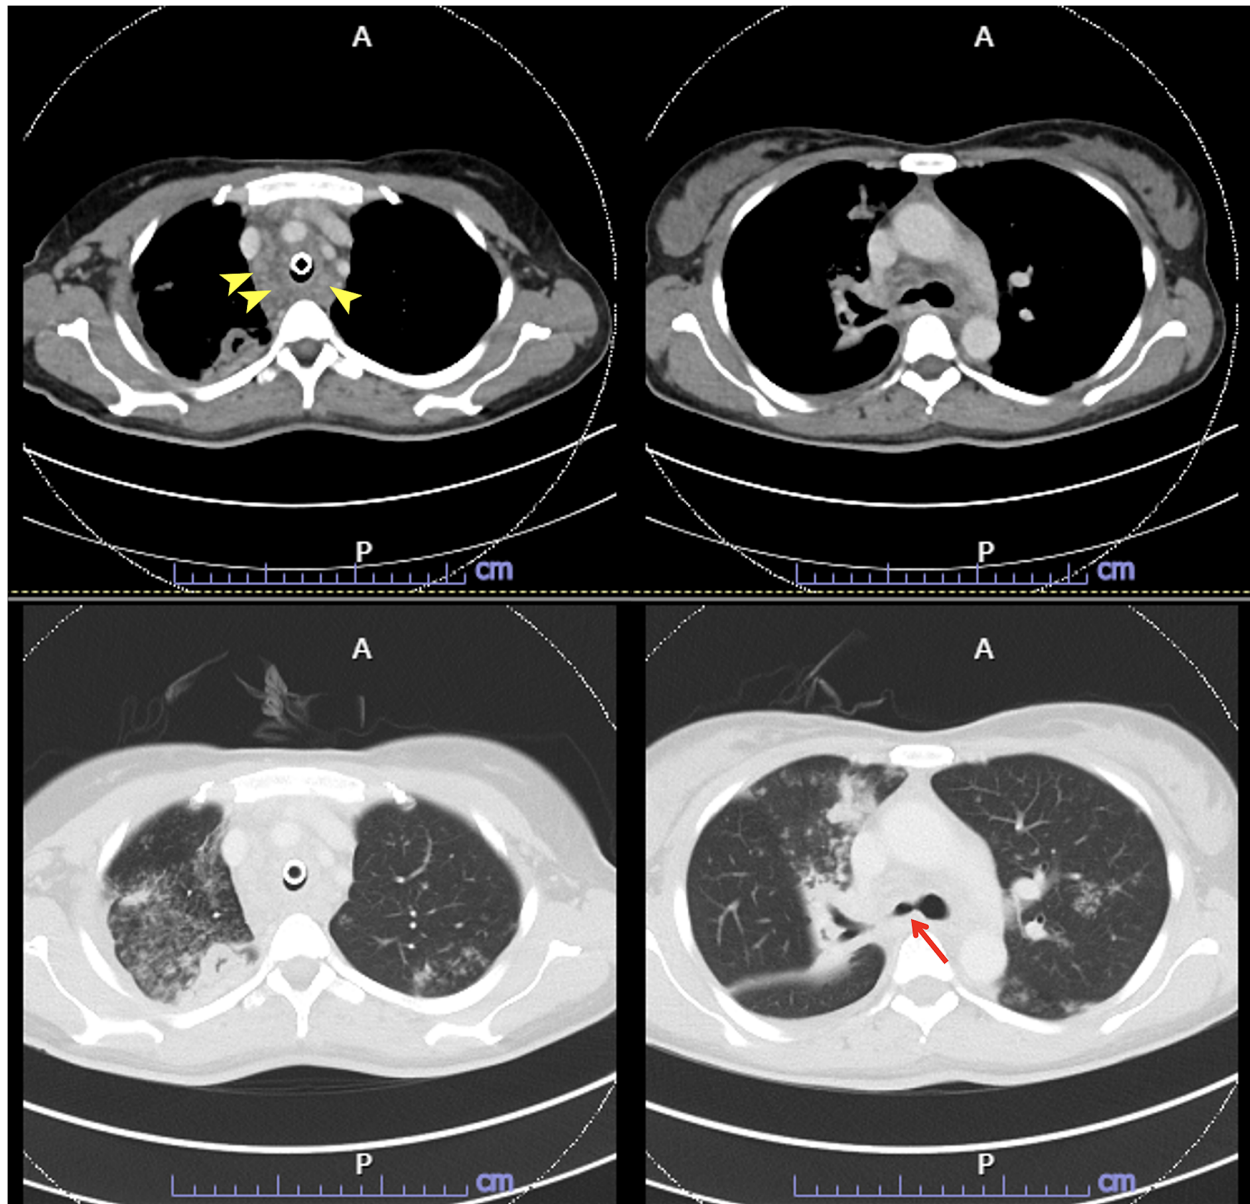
CT of the chest and neck (axial view) showing a segment of tracheal narrowing (arrow) with enhancing soft tissue and multiple lymph nodes surrounding distal trachea down to the right main bronchus (arrowheads)
